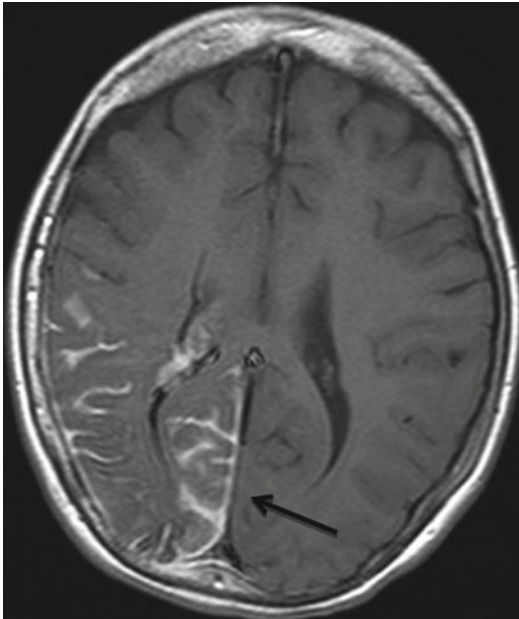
MRI of SWS patient showing right occipital hypervascularity as indicated by arrow
